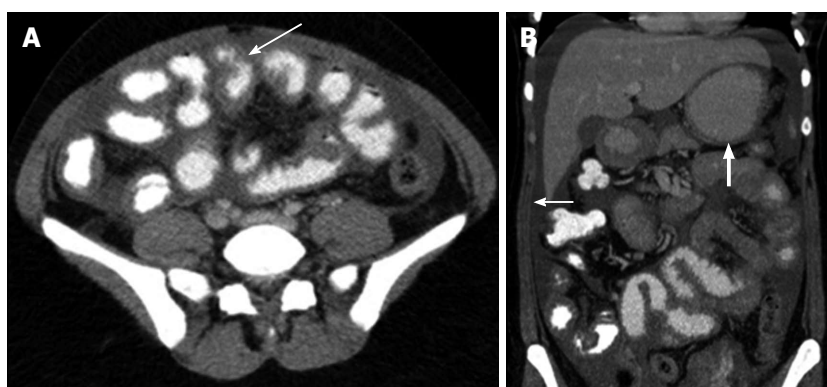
Findings on contrast-enhanced abdominal computed tomography. A: Sagittal section demonstrates thickened loops of small bowel (arrow); B: Coronal image demonstrates free peritoneal fluid (arrow), thickened loops of small bowel and circumferential mural thickening of the distal stomach (heavy arrow).
